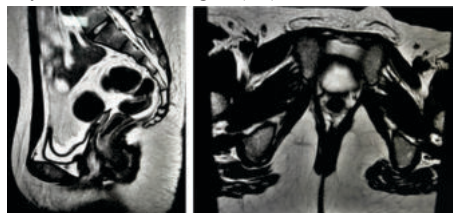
A) Sagittal section of MRI pelvis showing absence of vagina B) Coronal section of MRI pelvis showing rudimentary horns interconnected by fibrous band
